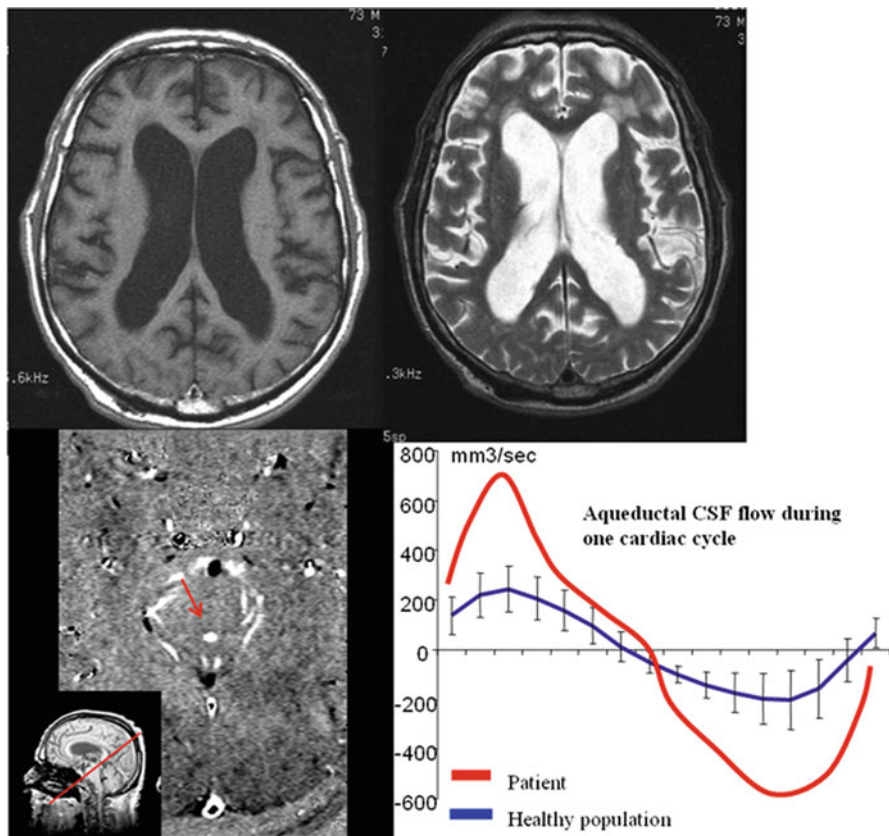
CSF flows in communicating hydrocephalus patient studied by PC-MRI. This 73-year-old man, with a history of hypertension, was referred for assessment of disorders of higher functions associated with gait disorders (ataxia) and sphincter disorders. Morphological MR demonstrated a dilation of the ventricular system, some deep cortical sulci, and nonspecific abnormalities of the periventricular white matter. The clinical and morphological assessment was unable to formally demonstrate the active nature of the ventricular dilation and the indication for ventricular shunting. The oscillatory flow volume measured in the cerebral aqueduct was very high, but normal CSF fluctuations were observed in the cervical subarachnoid spaces. The blood flow was small (334 mL/min), and the peak jugular vein outflow velocity was observed early after the arterial systolic peak. Ventriculoperitoneal shunting induced a marked clinical improvement with resolution of the gait disorders and sphincter disorders. Radiological follow-up demonstrated a reduction of ventricular volume. In this clinical case, demonstration of a markedly hyperdynamic ventricular system supported the indication for ventricular shunting in this patient; as for many authors, increased ventricular activity is predictive of a favourable outcome of shunting
